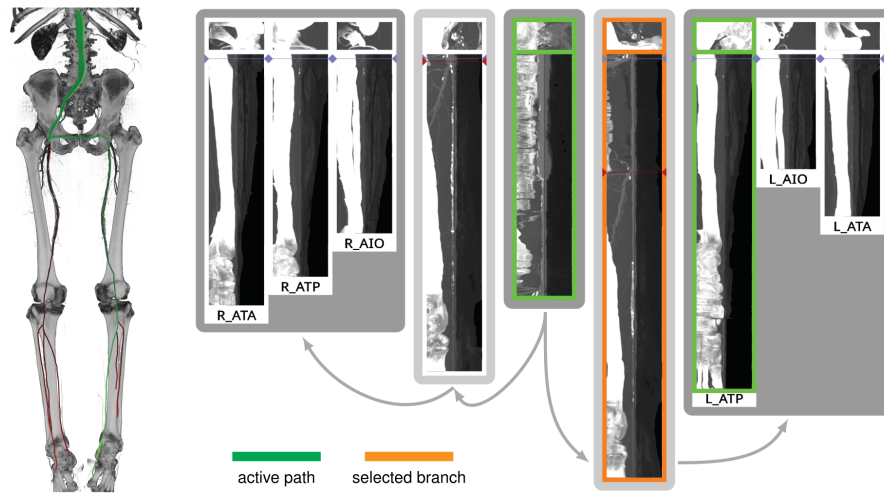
Anatomical layout of a peripheral CTA data set (right in 3D) showing several CFA visualizations arranged from the center to the left and right. Image from [220], courtesy of Gabriel Mistelbauer.
